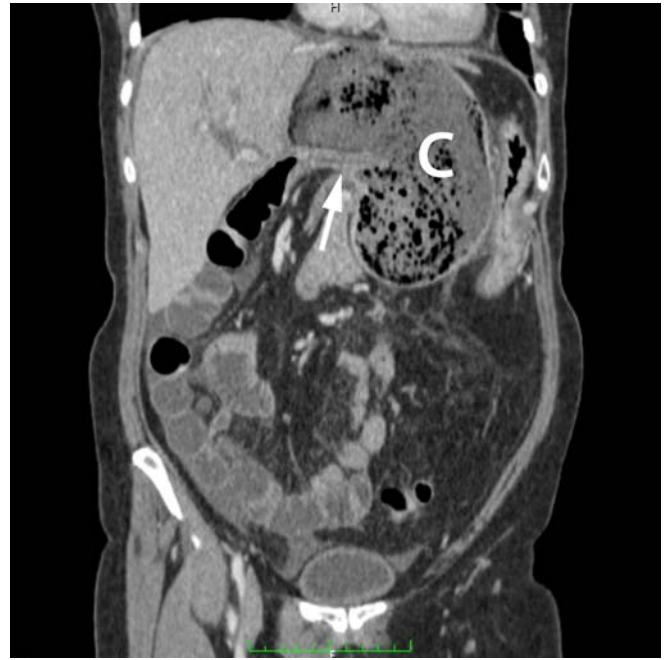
Coronal contrast-enhanced CT image showing the caecum (C) in the lesser sac. The location of the hernia is revealed by the beaking of the bowel at the foramen of Winslow (white arrow)
